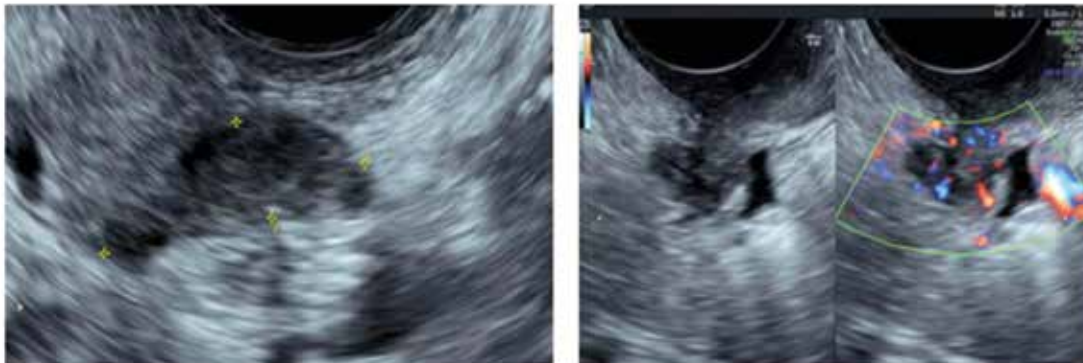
Ultrasound images of endometriotic nodules involving the uterosacral ligaments.<sup>25</sup>
